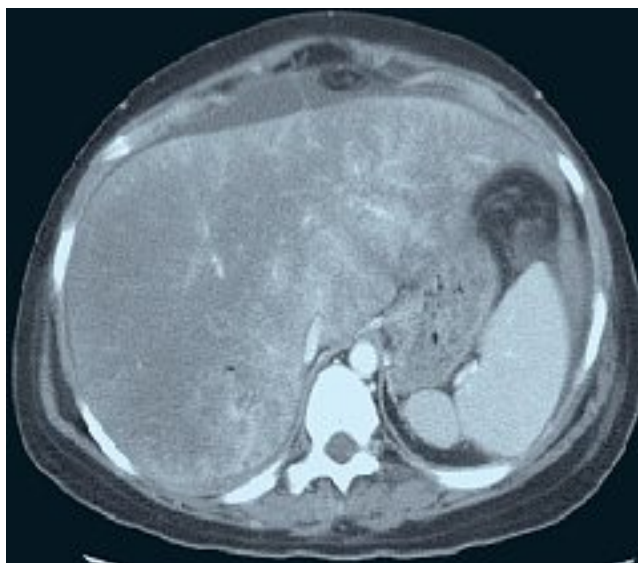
Budd-Chiari Syndrome. Contrast computed tomography of the abdomen reveals marked hepatic parenchymal heterogeneity (Figure 3A) with alternating areas of enhanced and decreased perfusion. Non-obstructing thrombus is noted within the inferior vena cava consistent with a type I Budd-Chiari pattern (Fig. 3B)
